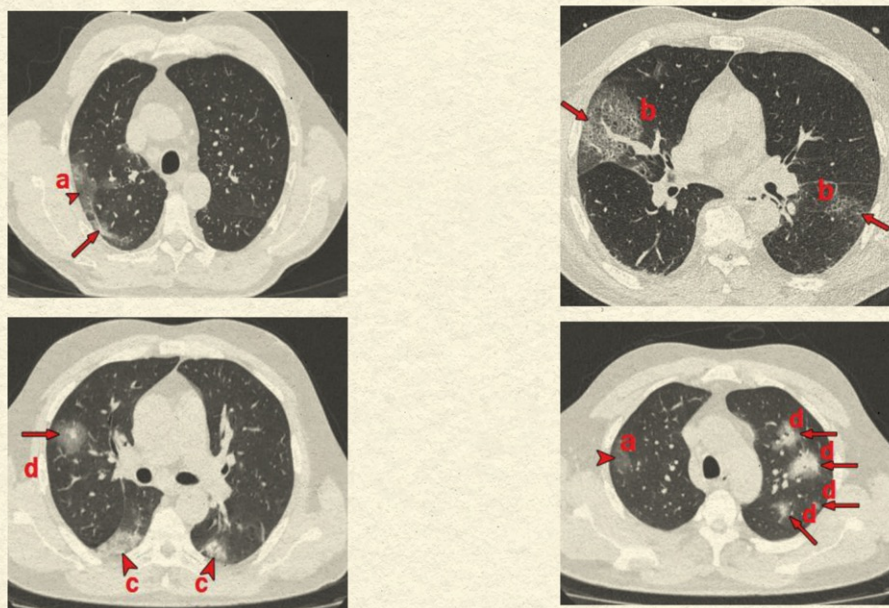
CT Thorax Features in Patient with COVID-19
